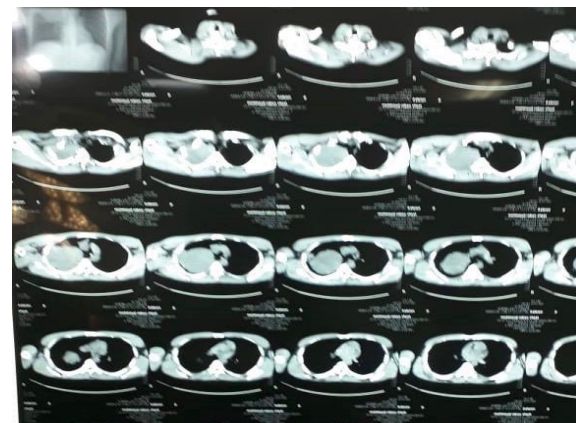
Mediastinal window of CT.
